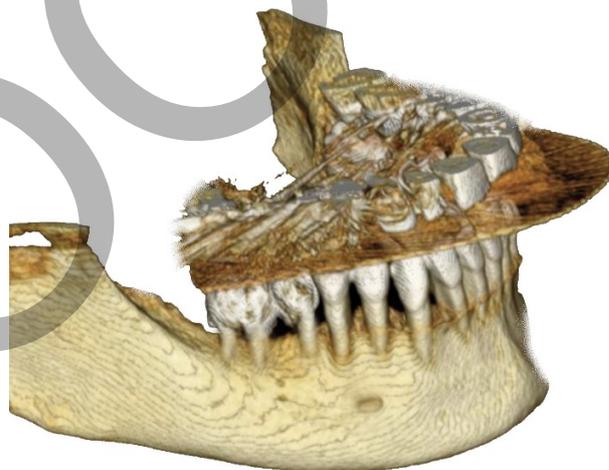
Volume rendering CBCT image of a MF in type 3 horizontal position (between the first and second premolars) and type 3 vertical position (below the level of the apices of the first and second premolars).
